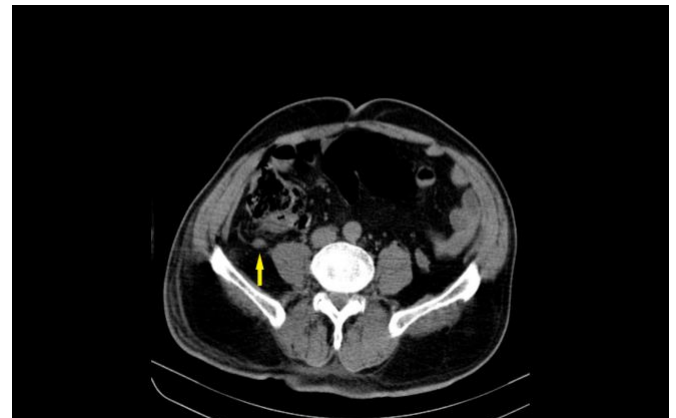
On CT scan, there was enlarged appendix tissue with peri-appendicular inflammation.
